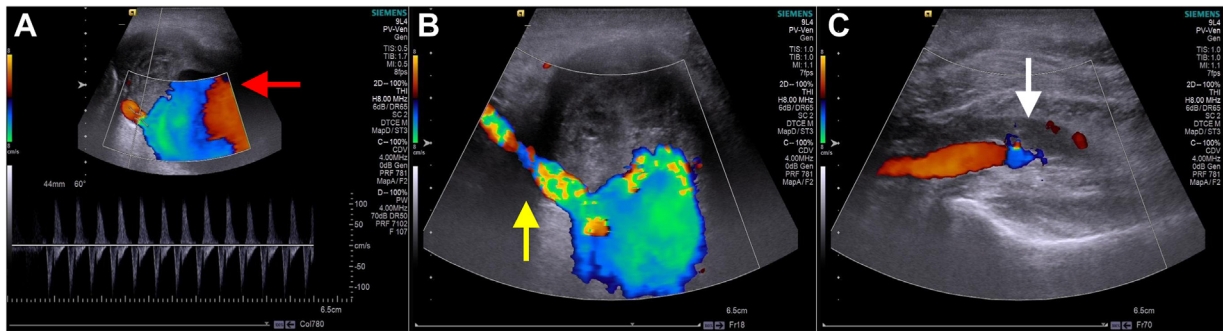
A,B, Color Doppler ultrasound scans showing classic yin-yang sign (red arrow) in the body of the pseudoaneurysm and revealing the pseudoaneurysm next to the popliteal artery (yellow arrow). C, Venous duplex ultrasound scan showing the noncompressible thrombosed popliteal vein (white arrow).
